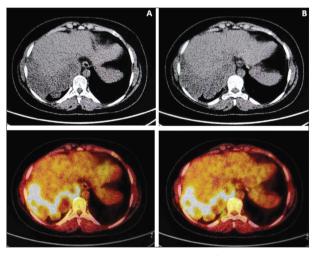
A, B – axial computed tomography, fused positron emission tomography/computed tomography images "kissing sign" liver and spleen
